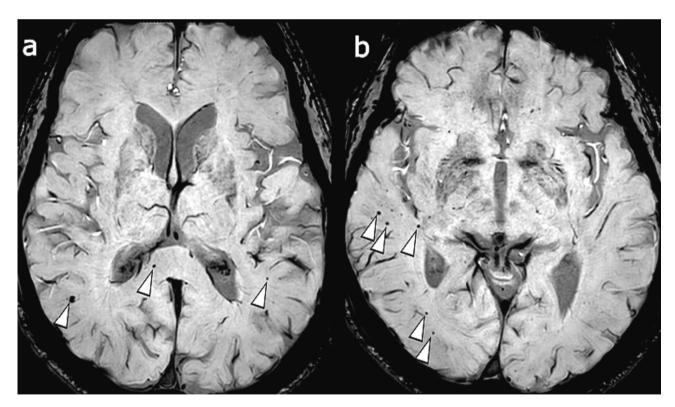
SWI sequence of brain MRI showing multiple CMBs in an ICU-treated individual with a total of 140 microbleeds. a CMBs in the right side of splenium and both temporal lobes b CMBs in the right temporo-occipital areas. Some of the CMBs are marked with arrowheads.
